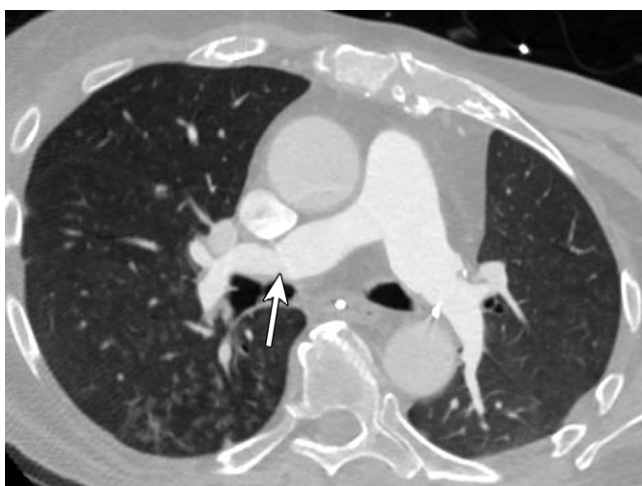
Image in a 58-year-old man with pulmonary artery stenosis identified at the first postoperative CT performed after bilateral lung transplantation for interstitial lung disease. Three-dimensional reconstructed axial chest CT image shows stenosis of the right main pulmonary artery (arrow) with relative lucency and hypovascularity of the right lung in the setting of right main pulmonary artery stenosis.
